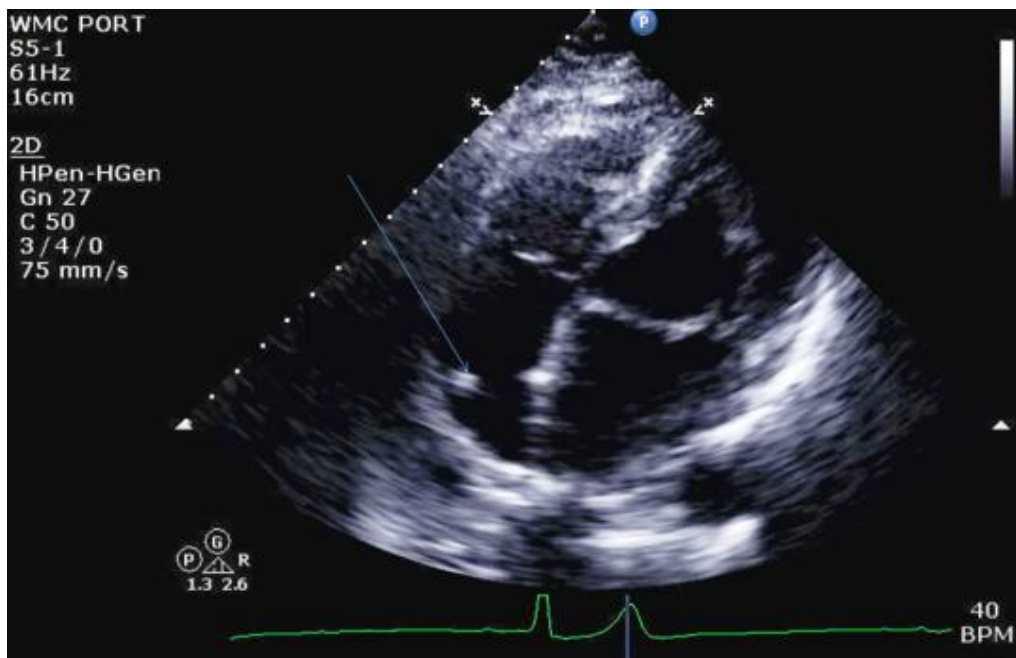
Transthoracic echocardiogram arrow pointing at echogenic destiny in the right atrium
